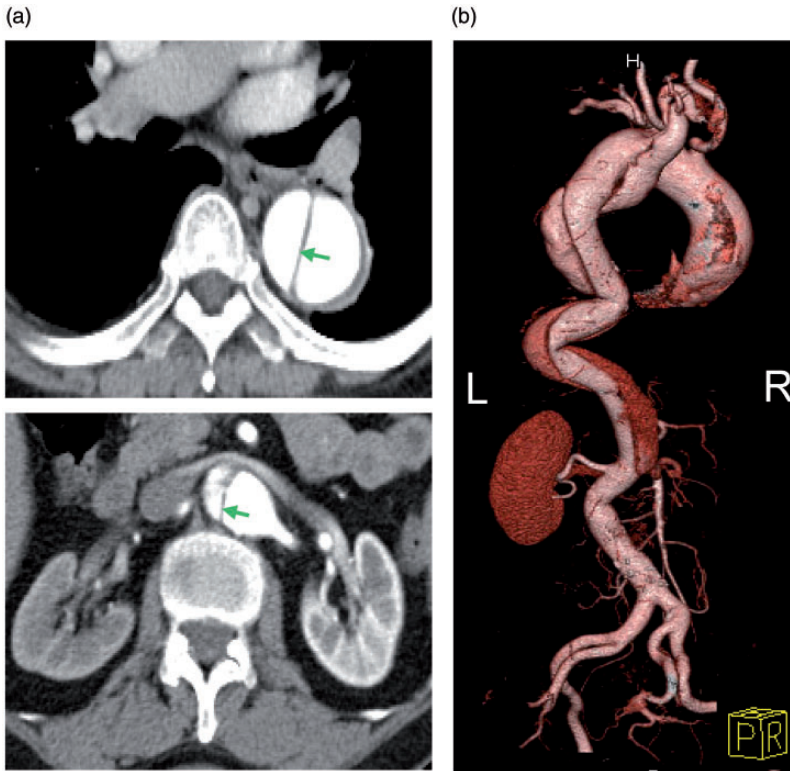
Eight-month follow-up. (a) Multidetector computed tomography scans showing aortic dissection (arrows, upper panel) with right renal artery involvement (arrows, lower panel). (b) Three-dimensional reconstruction showing the aortic dissection with the poorly perfused right kidney.
